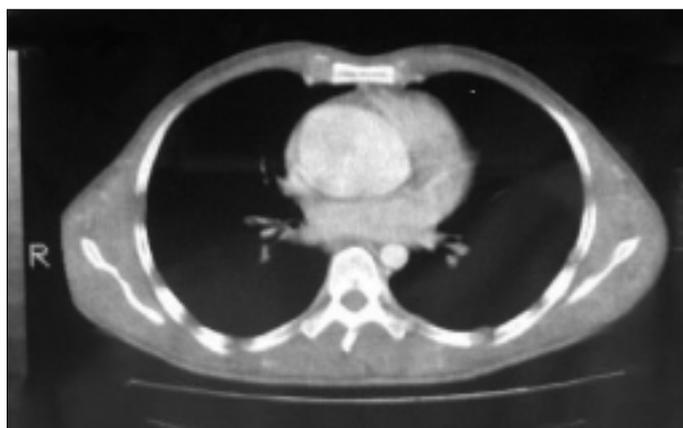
Preoperative computed tomographic scan shows aneurysm of the ascending aorta and coarctation of the descending aorta
